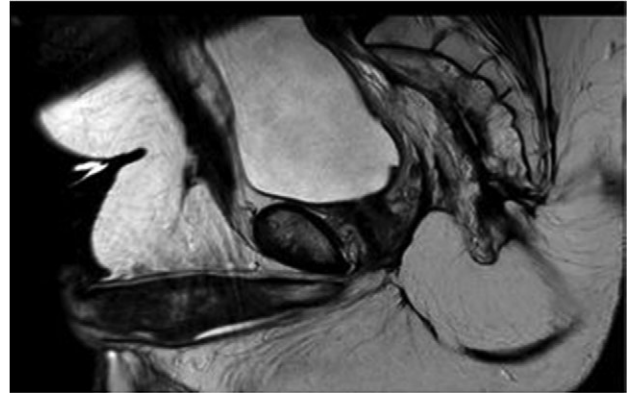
MRI pelvis large field T2 sagittal image through penile shaft showing the lesion involving the corpora cavernosum with extension in the spongiosum.
